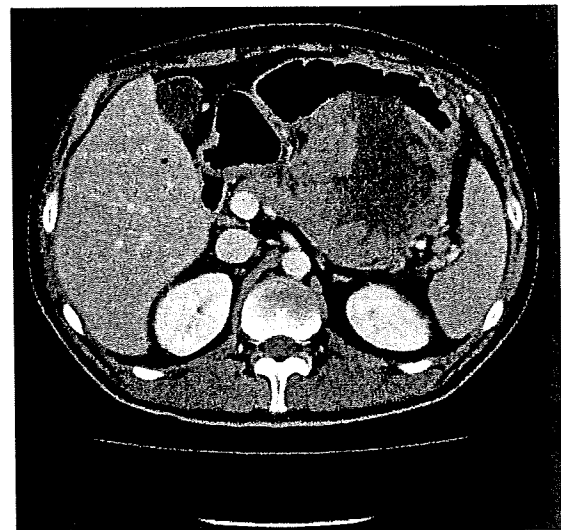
Abdominal computed tomography of Case 1 before treatment. The tumor appeared to be composed of cystic and solid components.
